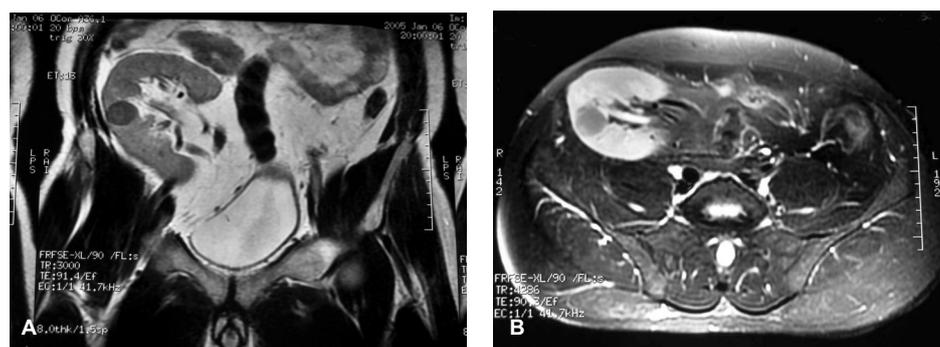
(A,B). The hyposignal mass on T1-weighted MRI on T2 weighted Image
